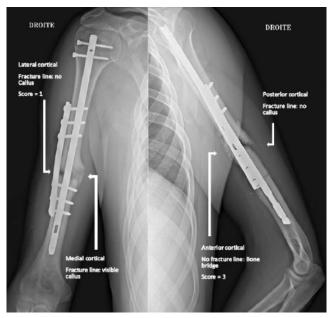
Radiographic Union Score for Tibial Fractures (RUST) by Whelan et al. Frontal and lateral X-ray images of humerus after surgical treatment of aseptic non-union and osteosynthesis by intramedullary nailing and screw plate. RUST total score = 7.
